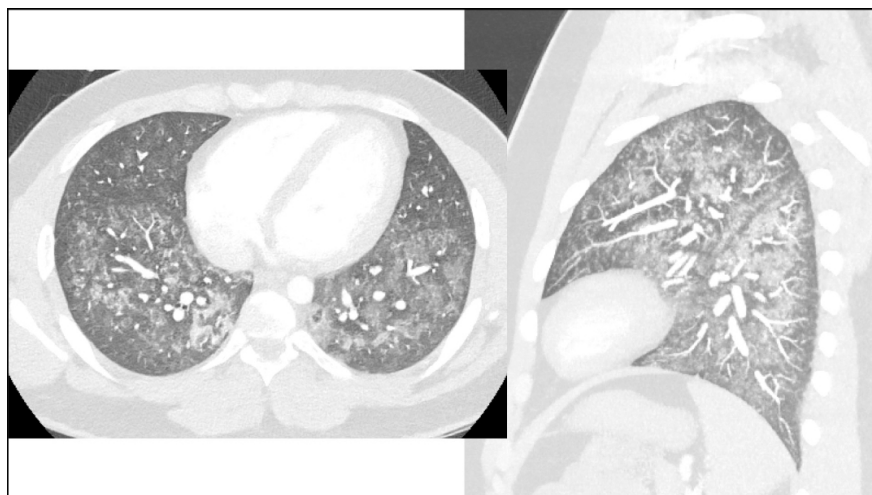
CT image demonstrates bilateral patchy ground glass opacities and consolidation with intralobular thickening
